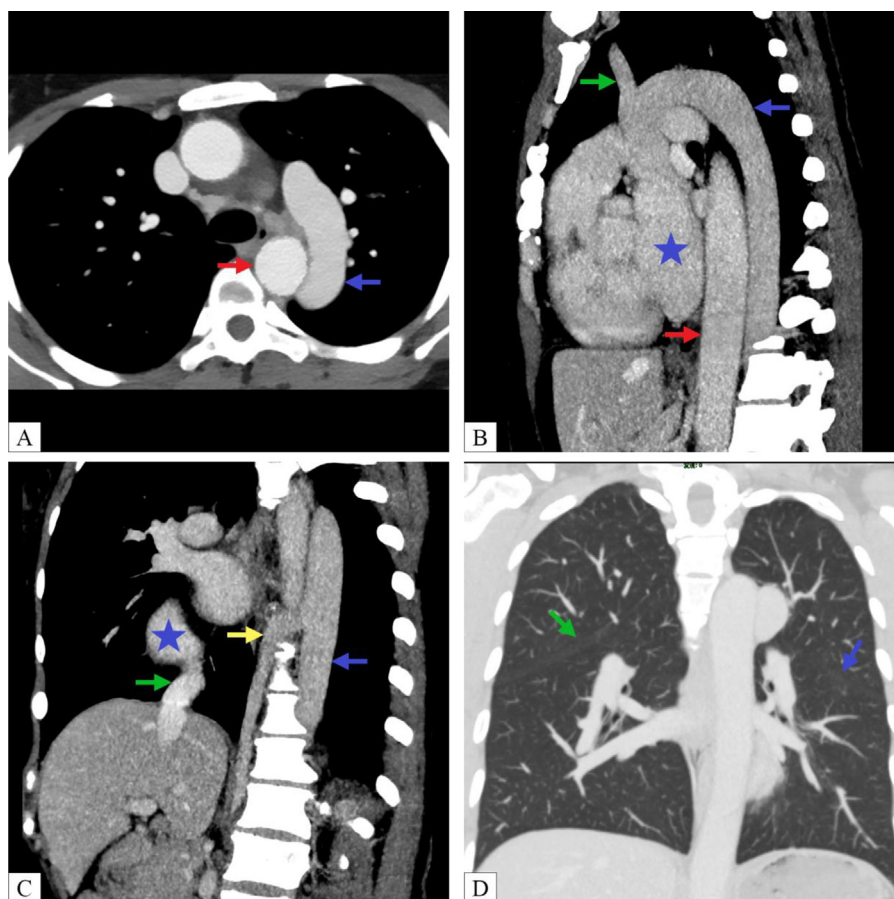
The patient's chest CT scan images. (A) CT-enhanced Mono E40kev arterial phase image (axial plane). The left inferior vena cava (blue arrowhead) lies to the left of the descending aorta (red arrowhead). (B) CT MIP image (sagittal plane). The left brachiocephalic vein (green arrowhead) joins the left inferior vena cava (blue arrowhead) and finally joins together into the right atrium (blue stars). The left inferior vena cava runs posterior to the descending aorta (red arrowhead). (C) CT MIP image (sagittal plane). The azygos vein (yellow arrowhead) drains into the left inferior vena cava (blue arrowhead) at the level of the 8 thoracic vertebra. The hepatic segment of the vena cava is absent, and direct drainage of the hepatic veins (green arrowhead) into the right atrium (blue stars). (D) CT MIP image (coronal plane). Heterotopia on the left side of both lungs, the right oblique fissure (green arrowhead) was more symmetrically positioned to the left oblique fissure (blue arrowhead), absence of the right horizontal fissure, and bilobar changes in the right lung.
